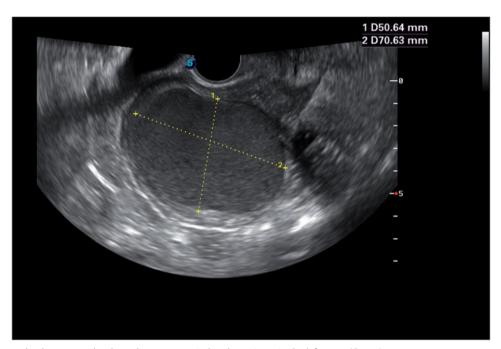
Transrectal gray-scale ultrasonography showed a 70-mm typical endometrioma in the left ovary (Case 3).
